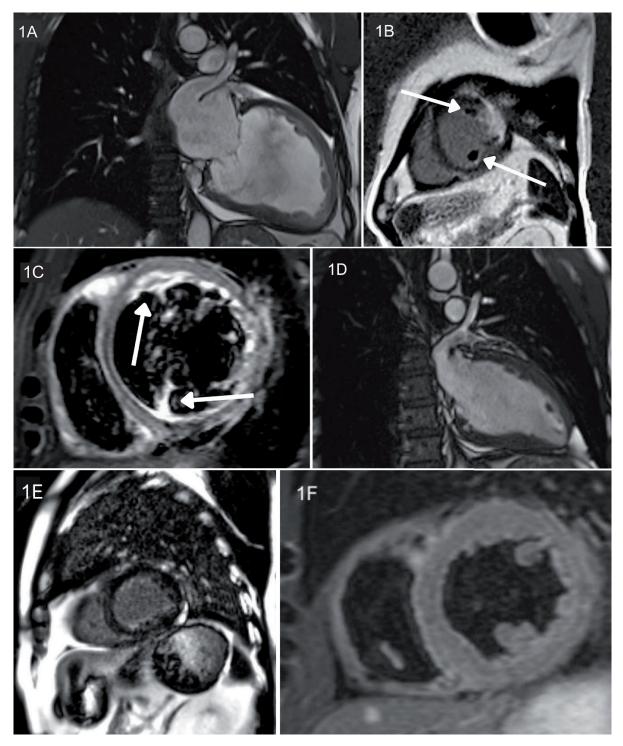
A – Cine-Magnetic Resonance Imaging 2-chamber view in end-diastole demonstrates left ventricular dilatation on admission. B – Magnetic Resonance Imaging 2-chamber short-axis, delayed enhancement images show intramural hyperenhancement (arrowheads) in the apical lateral wall and the adjacent mass (arrow) with no enhancement typical of thrombus formation in the left ventricle. C – Short-axis T2-weighted Magnetic Resonance Imaging shows myocardial oedema associated with acute myocarditis (arrows) predominantly involving the epicardial or transmural myocardium in the lateral wall on admission. D – Cine-Magnetic Resonance Imaging 2-chamber view in end-diastole demonstrates left ventricular reverse remodelling after 6 months of follow-up. E – agnetic Resonance Imaging 2-chamber short-axis delayed enhancement images show a reduction of the lesions shown in Figure 1B after 6 months. F – Short-axis T2-weighted magnetic resonance imaging shows the resolution of oedema, as shown in Figure 1C, after 6 months. Abbreviations: MRI – magnetic resonance imaging.
